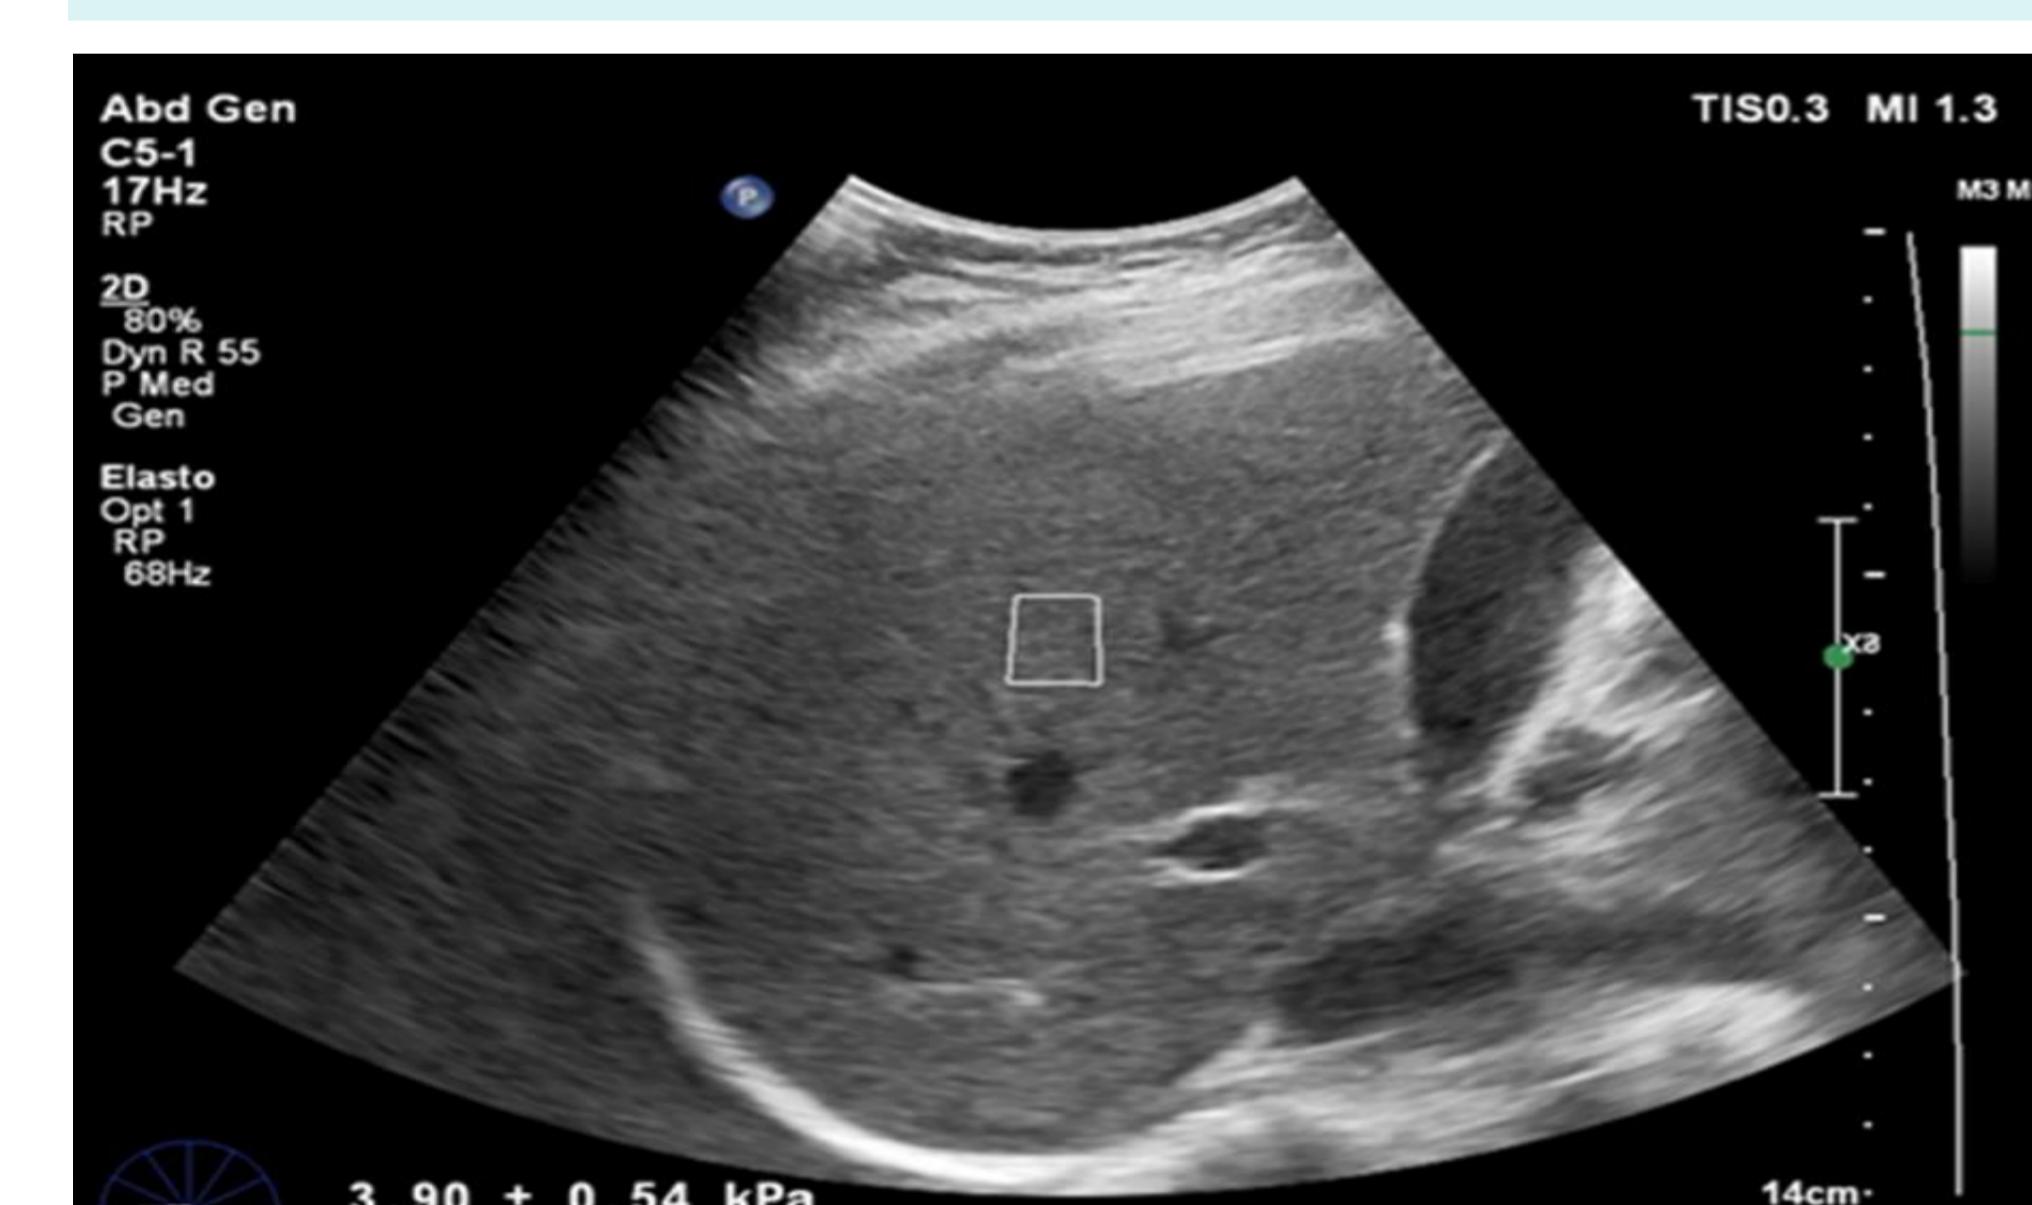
ElastPQ-PSWE measurement for liver stiffness on normal liver displayed over 2D ultrasound image of the right lobe of liver with ROI box placed away from liver capsule and vessels.
